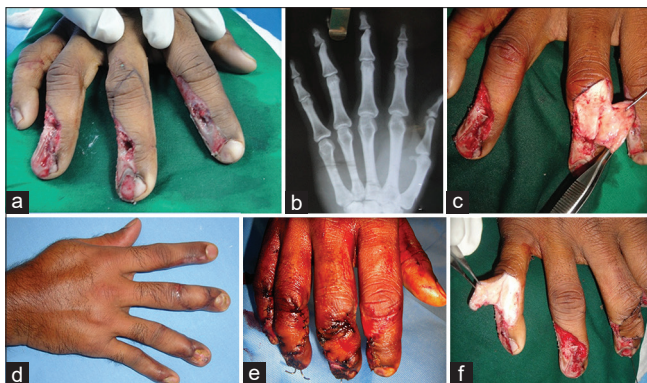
(a) Deep abrasion injury over the dorsum of index, middle, ring and little fingers with exposed distal inter-phalangeal joint of the middle, ring and little fingers with marking for the hatchet flap. (b) X-ray hand showing involvement of the distal inter-phalangeal joint more in ring and middle fingers. (c) The elevated hatchet flap over the middle finger. (d) Rotation flap elevated over the little finger and the closure of the hatchet flap over the middle finger. (e) Flap inset immediate post-operative. (f) 2 months post-operative result showing the well-settled hatchet and rotation flaps
